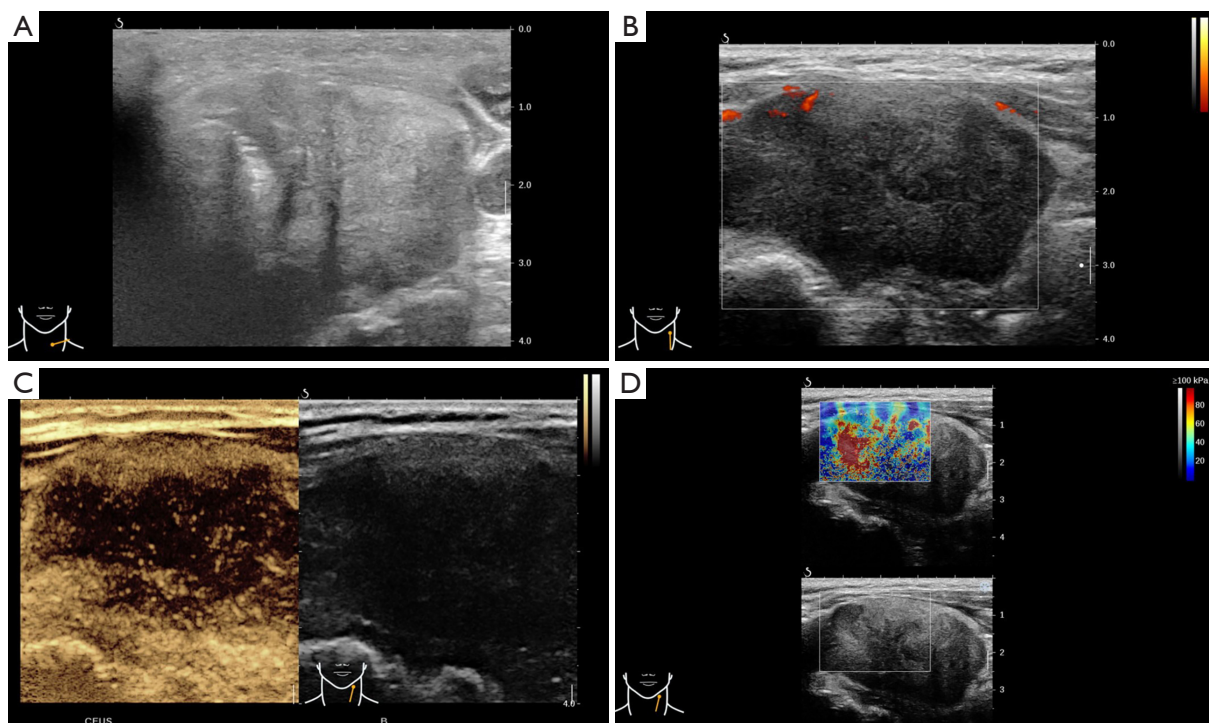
Ultrasound images of tracheal adenoid cystic carcinoma with thyroid invasion. (A,B) Conventional ultrasound shows a hypoechoic nodule in the left lobe and isthmus of the thyroid, adjacent to the trachea and the surrounding dorsal membra. The boundary of the nodule is unclear, the shape is irregular, and there is micro-calcification inside. (C) CEUS shows that the nodule is unevenly enhanced, with iso-enhancement in the periphery and hypo-enhancement in most of the central area. (D) Shear wave elastography shows that the nodule is hard in texture. CEUS, contrast-enhanced ultrasound.
